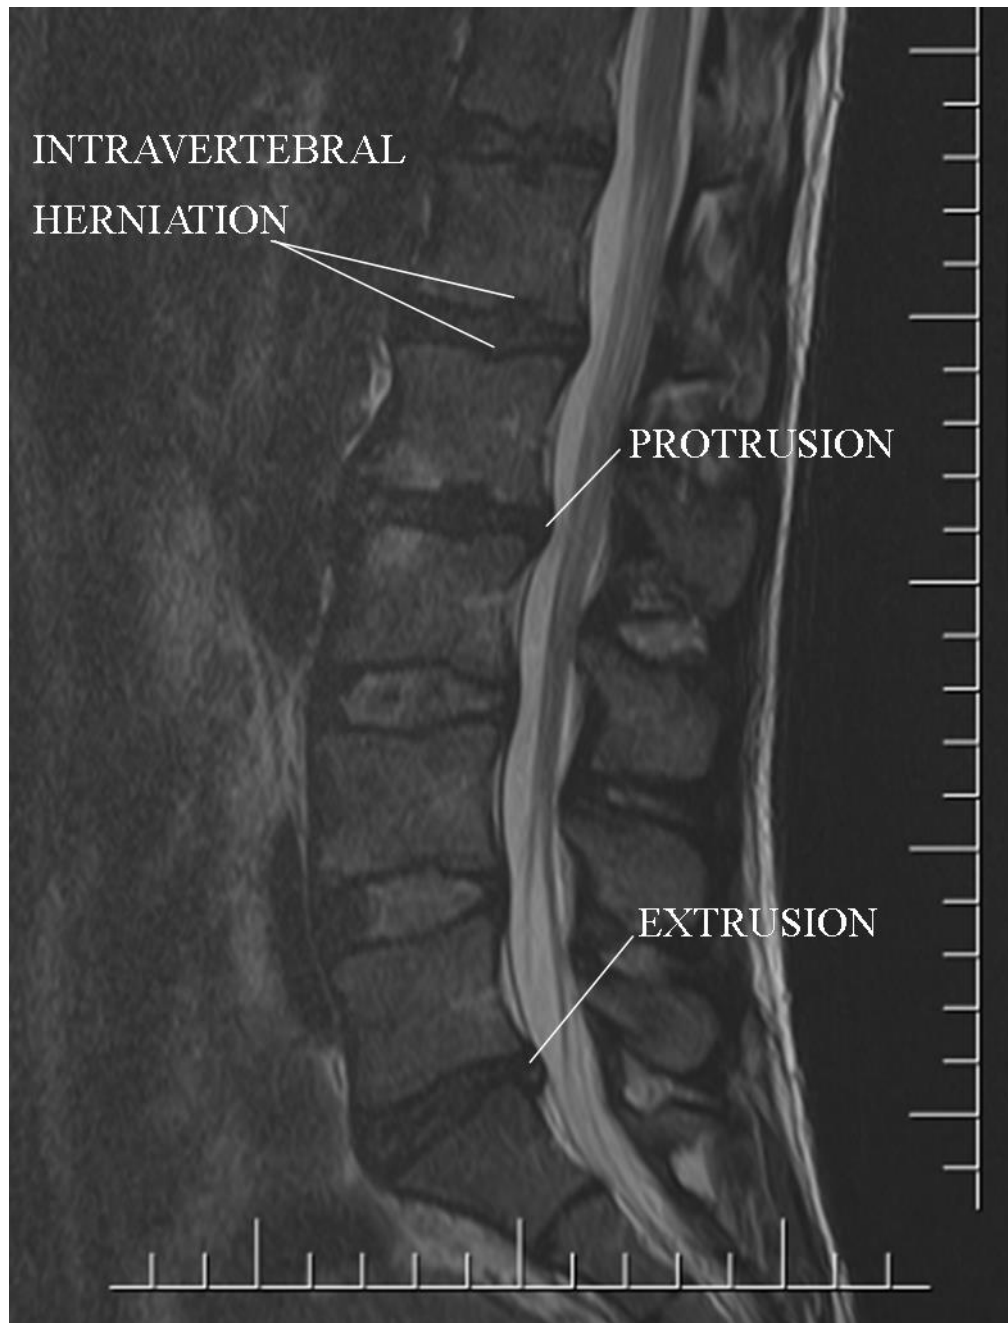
MRI image of the lumbar spine showing Protrusion (displaced disc material beyond the disc space with the edges of the disc material being less than the distance between the edges of the base in the same plane), Extrusion (displacement of disc material beyond the disc space with the edges of the displaced disc material being greater than the distance between the edges of the base) and Intravertebral Herniation (a cranio-caudal herniation of disc material through a break in the vertebral endplate). Magnification: 0.65 X
